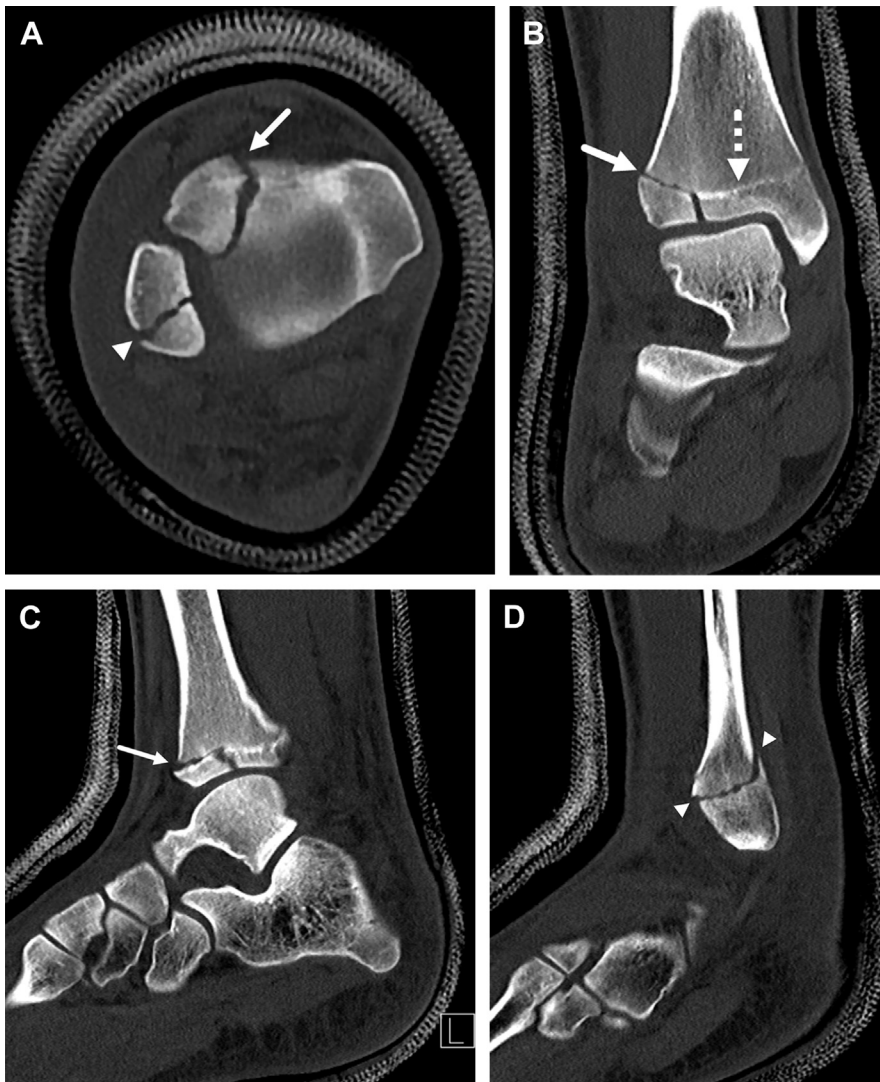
Salter-Harris type III fracture of the distal tibia (Tillaux fracture) and SH type II fracture of the distal fibula in a 16-year-old female gymnast. (A) Axial, (B) coronal, and (C) sagittal CT images of the tibia demonstrate a SH type III fracture across the anterolateral region of the distal tibial physis with a vertical epiphyseal component (arrows). The medial physis demonstrate physiologic closure (interrupted arrow). There is approximately 3 mm of displacement of the distal tibial articular surface. (D) Sagittal CT image of the distal fibula demonstrates a SH type II fracture across the distal tibial physis and posterior metaphysis (arrowheads). The patient underwent open reduction and interval fixation of the tibial fracture.
